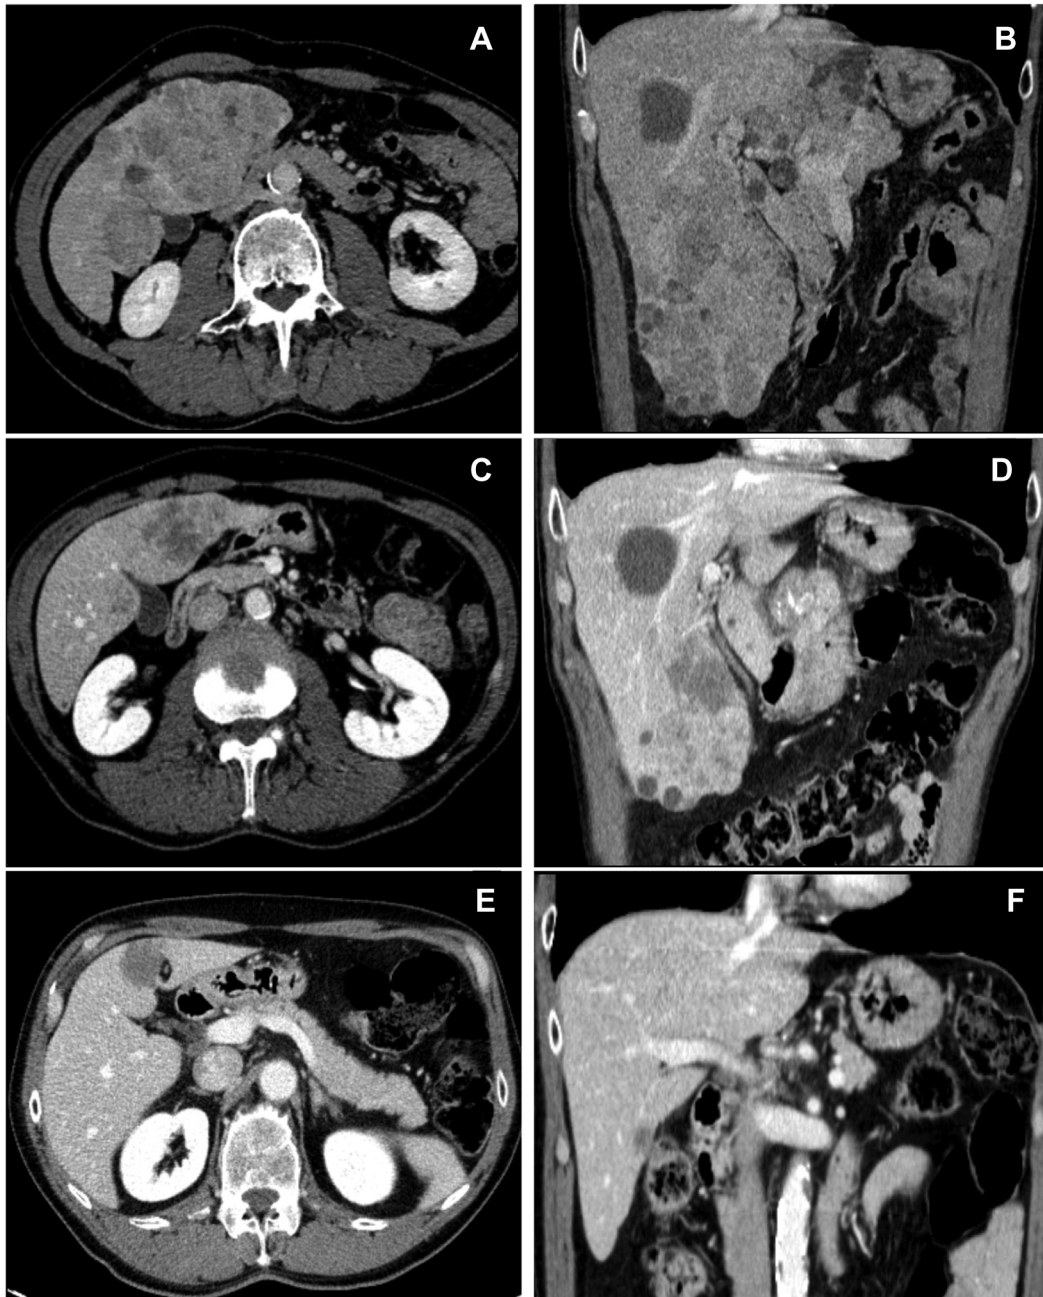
Contrast enhanced CT scan axial (A) and coronal (B) view at the time of diagnosis; contrast enhanced CT scan axial (C) and coronal (D) view after 3 months of treatment; contrast enhanced CT scan axial (E) and coronal (F) view after 11 months. CT: Computed tomography.
